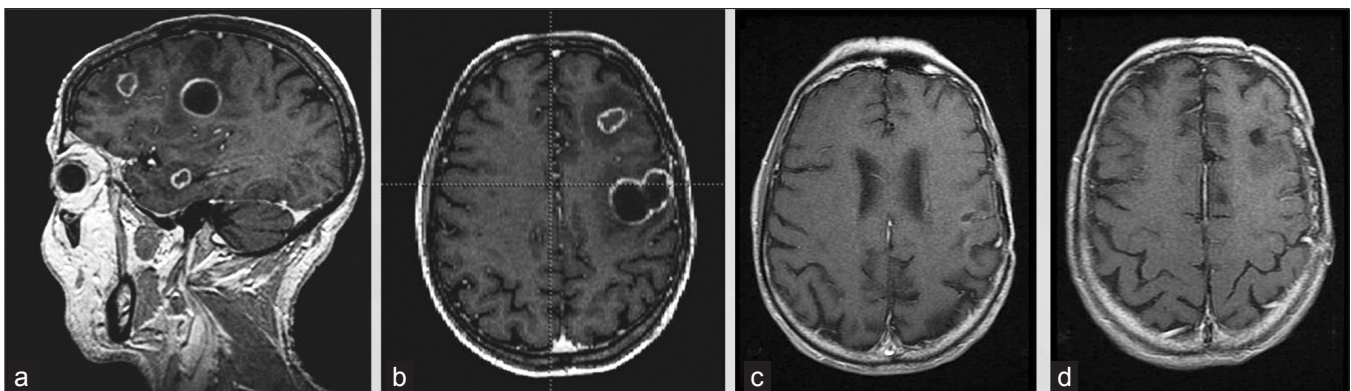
Images for Case 3. (a, b) The presurgical magnetic resonance imaging scan with multiple contrast-enhancing lesions. (c, d) The post-treatment MRI showing resolution of lesions, with areas of encephalomalacia
